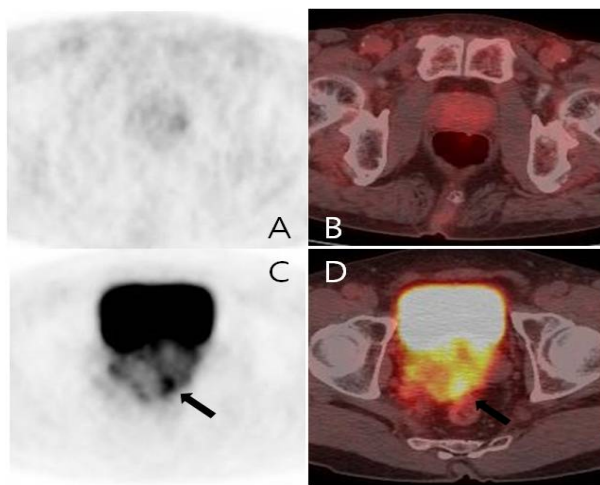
Hypermetabolism Pattern in a ^{18}F -FDG-PET/CT Scan of the Prostate. A diffuse uptake pattern on axial FDG PET images of the prostate and FDG PET/CT fusion images (A, B). A Discrete uptake pattern on axial FDG PET images of the prostate and FDG PET/CT fusion images (C, D)
